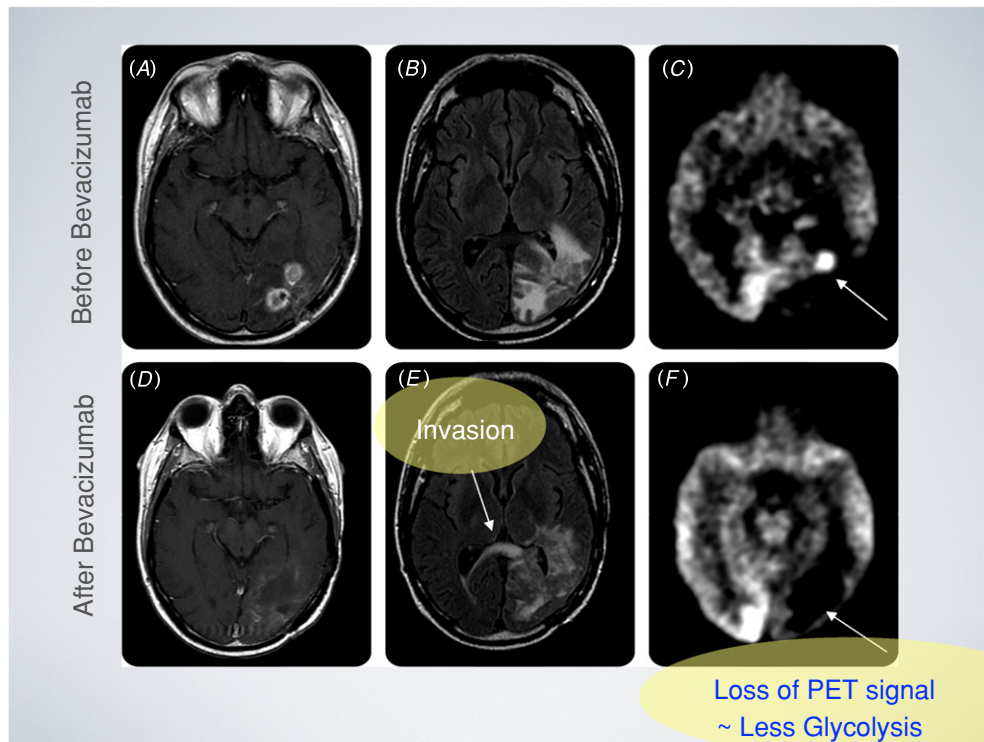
In this series of images, adapted from Iwamoto *et al* [30] we see three images from the same patient before and after treatment with anti-angiogenic therapy, in this case bevacizumab. The top three images, representative of high α , show high glycolysis and low invasion. After treatment with bevacizumab, we see a reduction in glycolytic fraction (blunting of FDG-PET avidity) and the promotion of invasion, as predicted by our model.
